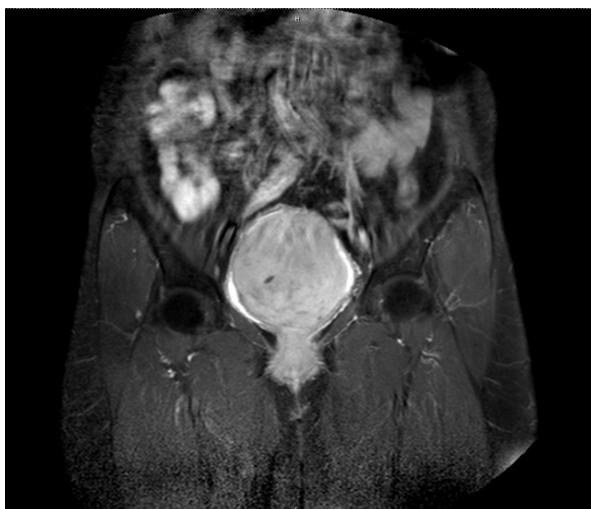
Coronal T2-weighted magnetic resonance imaging demonstrated a heterogeneous hypo-intensity intravesical mass, size 9.4x8.9x7.7 cm.
